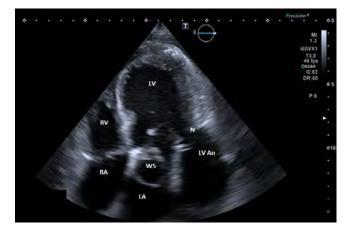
Transthoracic apical 4-chamber 2D view showing large aneurysmal sac with narrow neck and the windsock deformity opening into the left atrium. LV – left ventricle, N – neck of the aneurysm, LV An – left ventricle aneurysmal sac, WS – windsock deformity, RA – right atrium, RV – right ventricle
